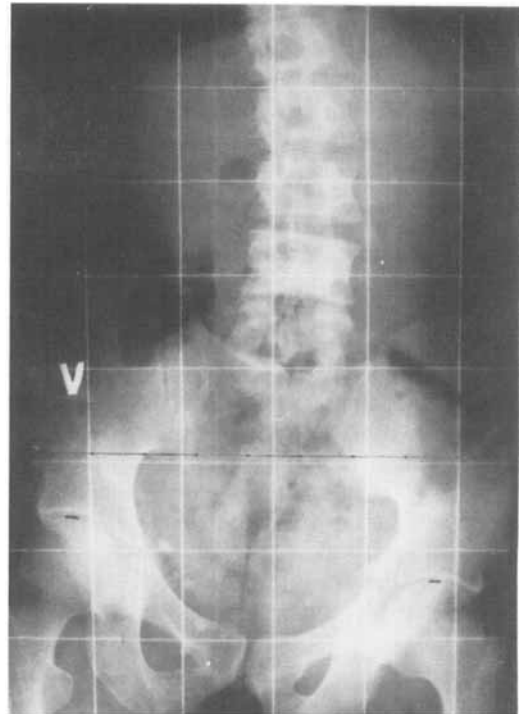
Radiograph obtained in the erect posture showing the hip joints and the lumbar spine. The proximal level of the femoral head on both sides is indicated.
